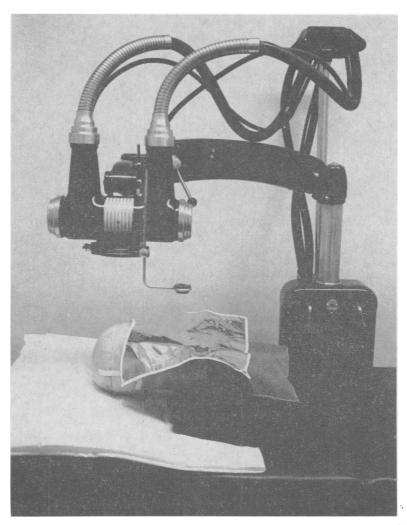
Arrangement of head and x-ray tube for an exposure position, and leaded rubber shielding used for rest of body.
